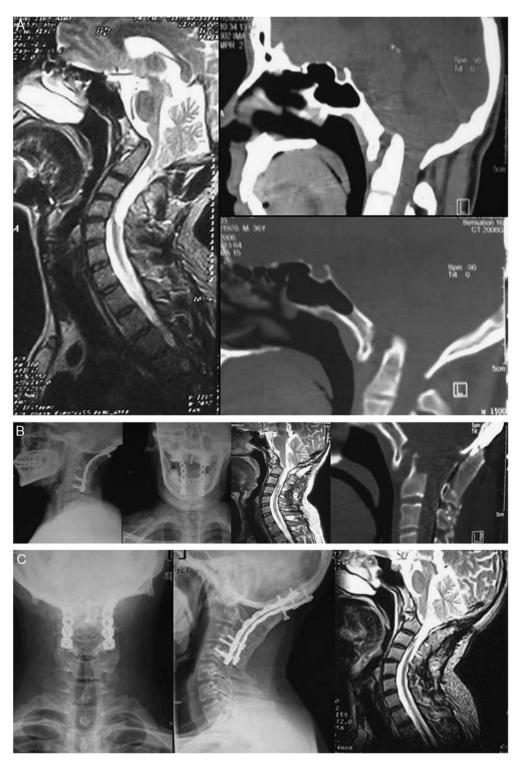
Data of patient no. 3. Patient no. 3 is a 36-year-old male. Operation time: July 2006. Diagnosis: basilar invagination. A, Preoperative computed tomography (CT) and magnetic resonance imaging (MRI) shows long odontoid into the foramen magnum caused the compression of the medulla oblongata and an enlargement in the cervical region in the spinal cord. B, Postoperative x-ray, CT, and MRI shows that bone graft and plate fixation were satisfactory. CT and MRI shows that the resection of the odontoid and the significantly enlarged neural canal. C, An x-ray and MRI performed 34 months after surgery shows that the canal of the occipital nerve was significantly enlarged; the signal from the local spinal cord and fusion was good.
